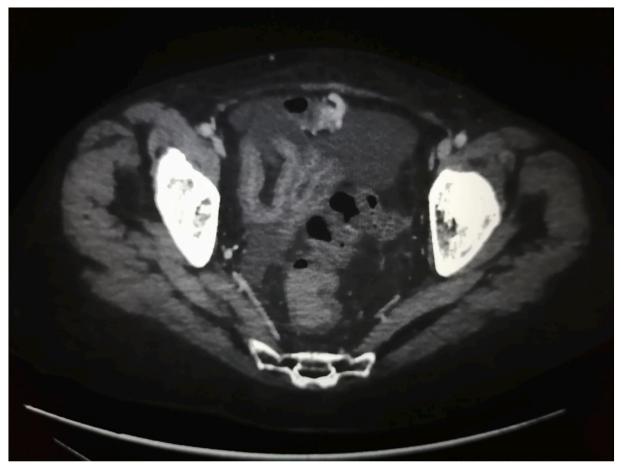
CT scan in the axial plane showing the ileal varices.
